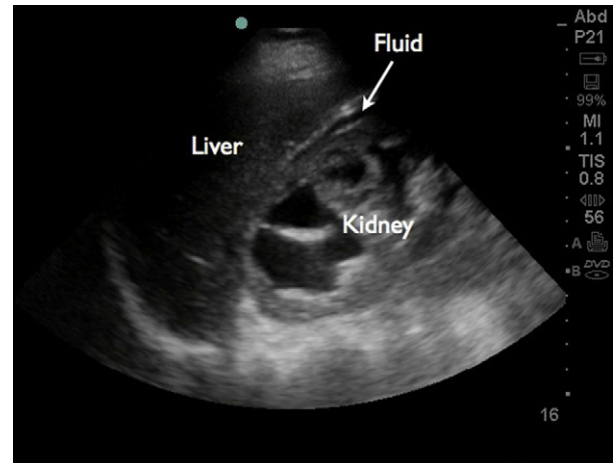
Longitudinal ultrasound image demonstrating free fluid between the liver and kidney.
